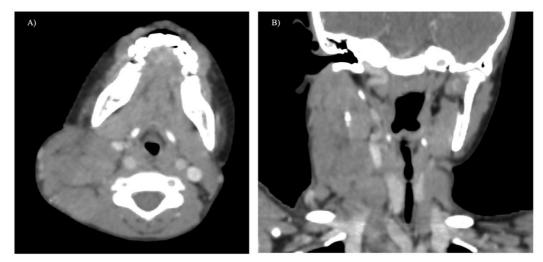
In a classical Hodgkin's lymphoma, contrast-enhanced CT shows multiple enlarged discrete nodal masses, surrounding the carotid vessels without obvious infiltration.
